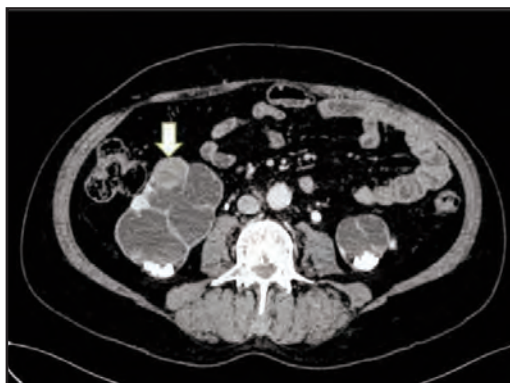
Axial CT renal 4-phase scan showing a rounded, hypodense soft tissue lesion at right lower pole (arrow)
